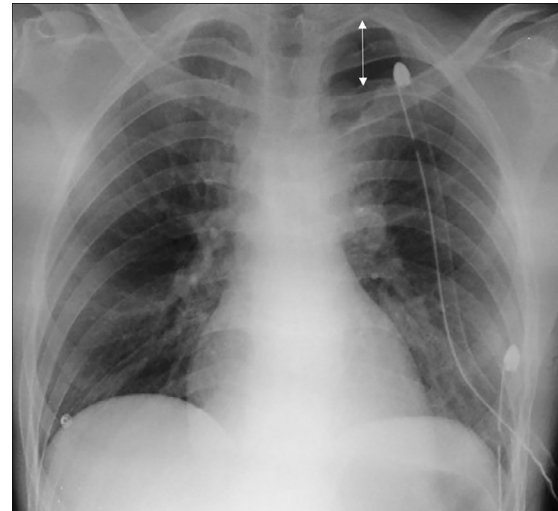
Chest x-ray performed on supine decubitus after chest tubes positioning. Pneumothorax is better appreciable within the left lung apex (arrows).
